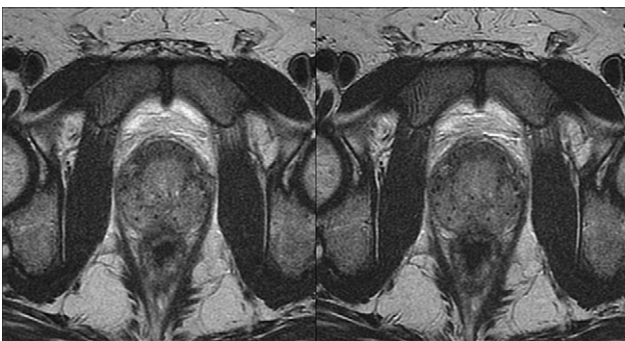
Magnetic resonance images through the midprostate. A bandwidth of 120 Hz/pixel was used in the image on the left, and the image on the right was taken using a bandwidth of 80 Hz/pixel. These images were taken from the same patient.
